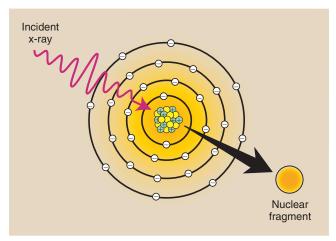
Photodisintegration is an interaction between high-energy x-rays and the nucleus. The x-ray is absorbed by the nucleus, and a nuclear fragment is emitted.
